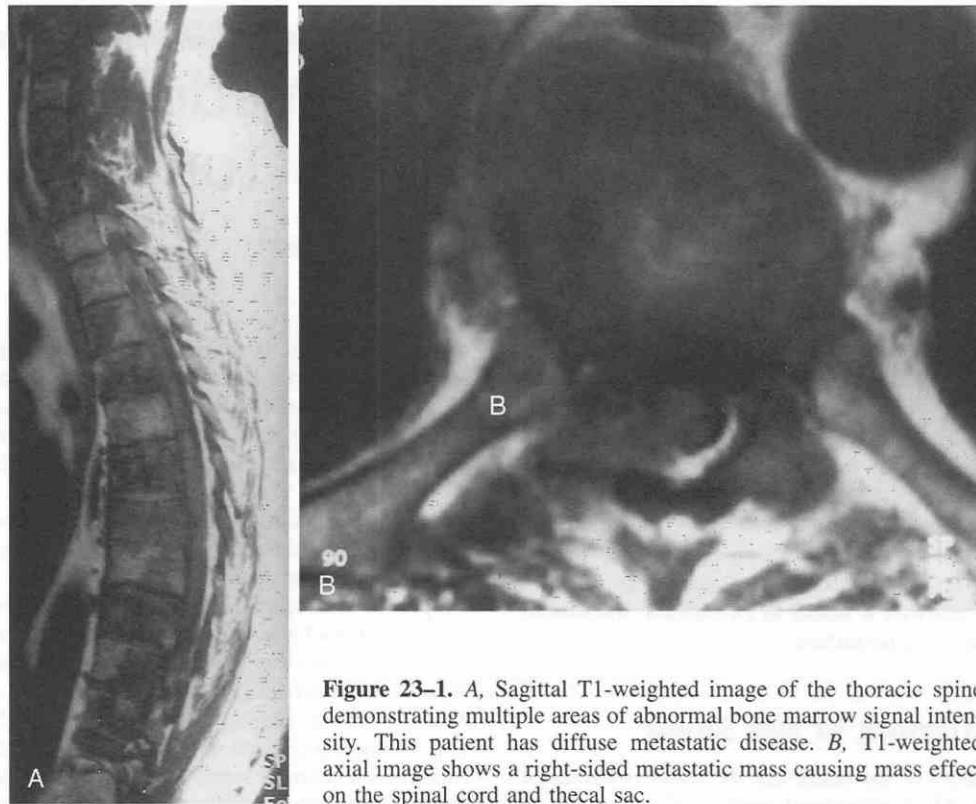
A, Sagittal T1-weighted image of the thoracic spine demonstrating multiple areas of abnormal bone marrow signal intensity. This patient has diffuse metastatic disease. B, T1-weighted axial image shows a right-sided metastatic mass causing mass effect on the spinal cord and thecal sac.
